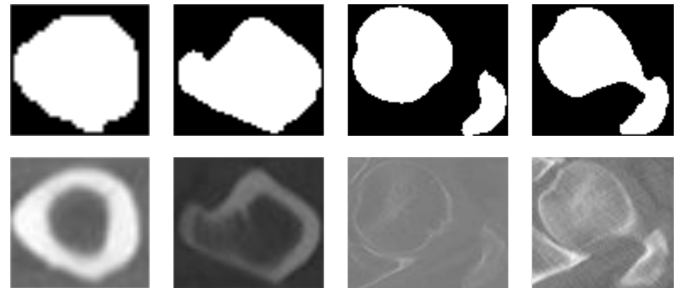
Sample masks images (upper row) with the corresponding CT images (bottom row).
